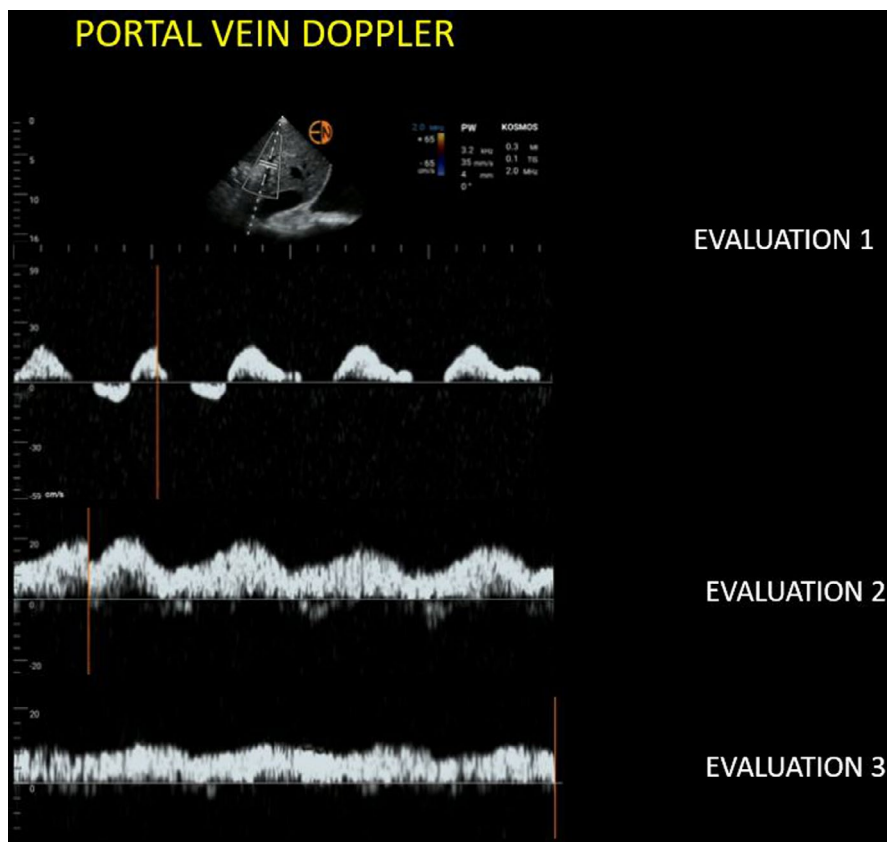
Portal vein Doppler at the time of nephrology consult (evaluation 1), 2 days after starting diuretic therapy (evaluation 2), and final follow-up 2 days later (evaluation 3). Note the improvement in pulsatility (normal is less than 30%)
